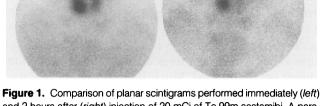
Comparison of planar scintigrams performed immediately (*left*) and 2 hours after (*right*) injection of 20 mCi of Tc-99m-sestamibi. A parathyroid tumor near the inferior pole of the right thyroid lobe is best seen in the delayed scintigram.
